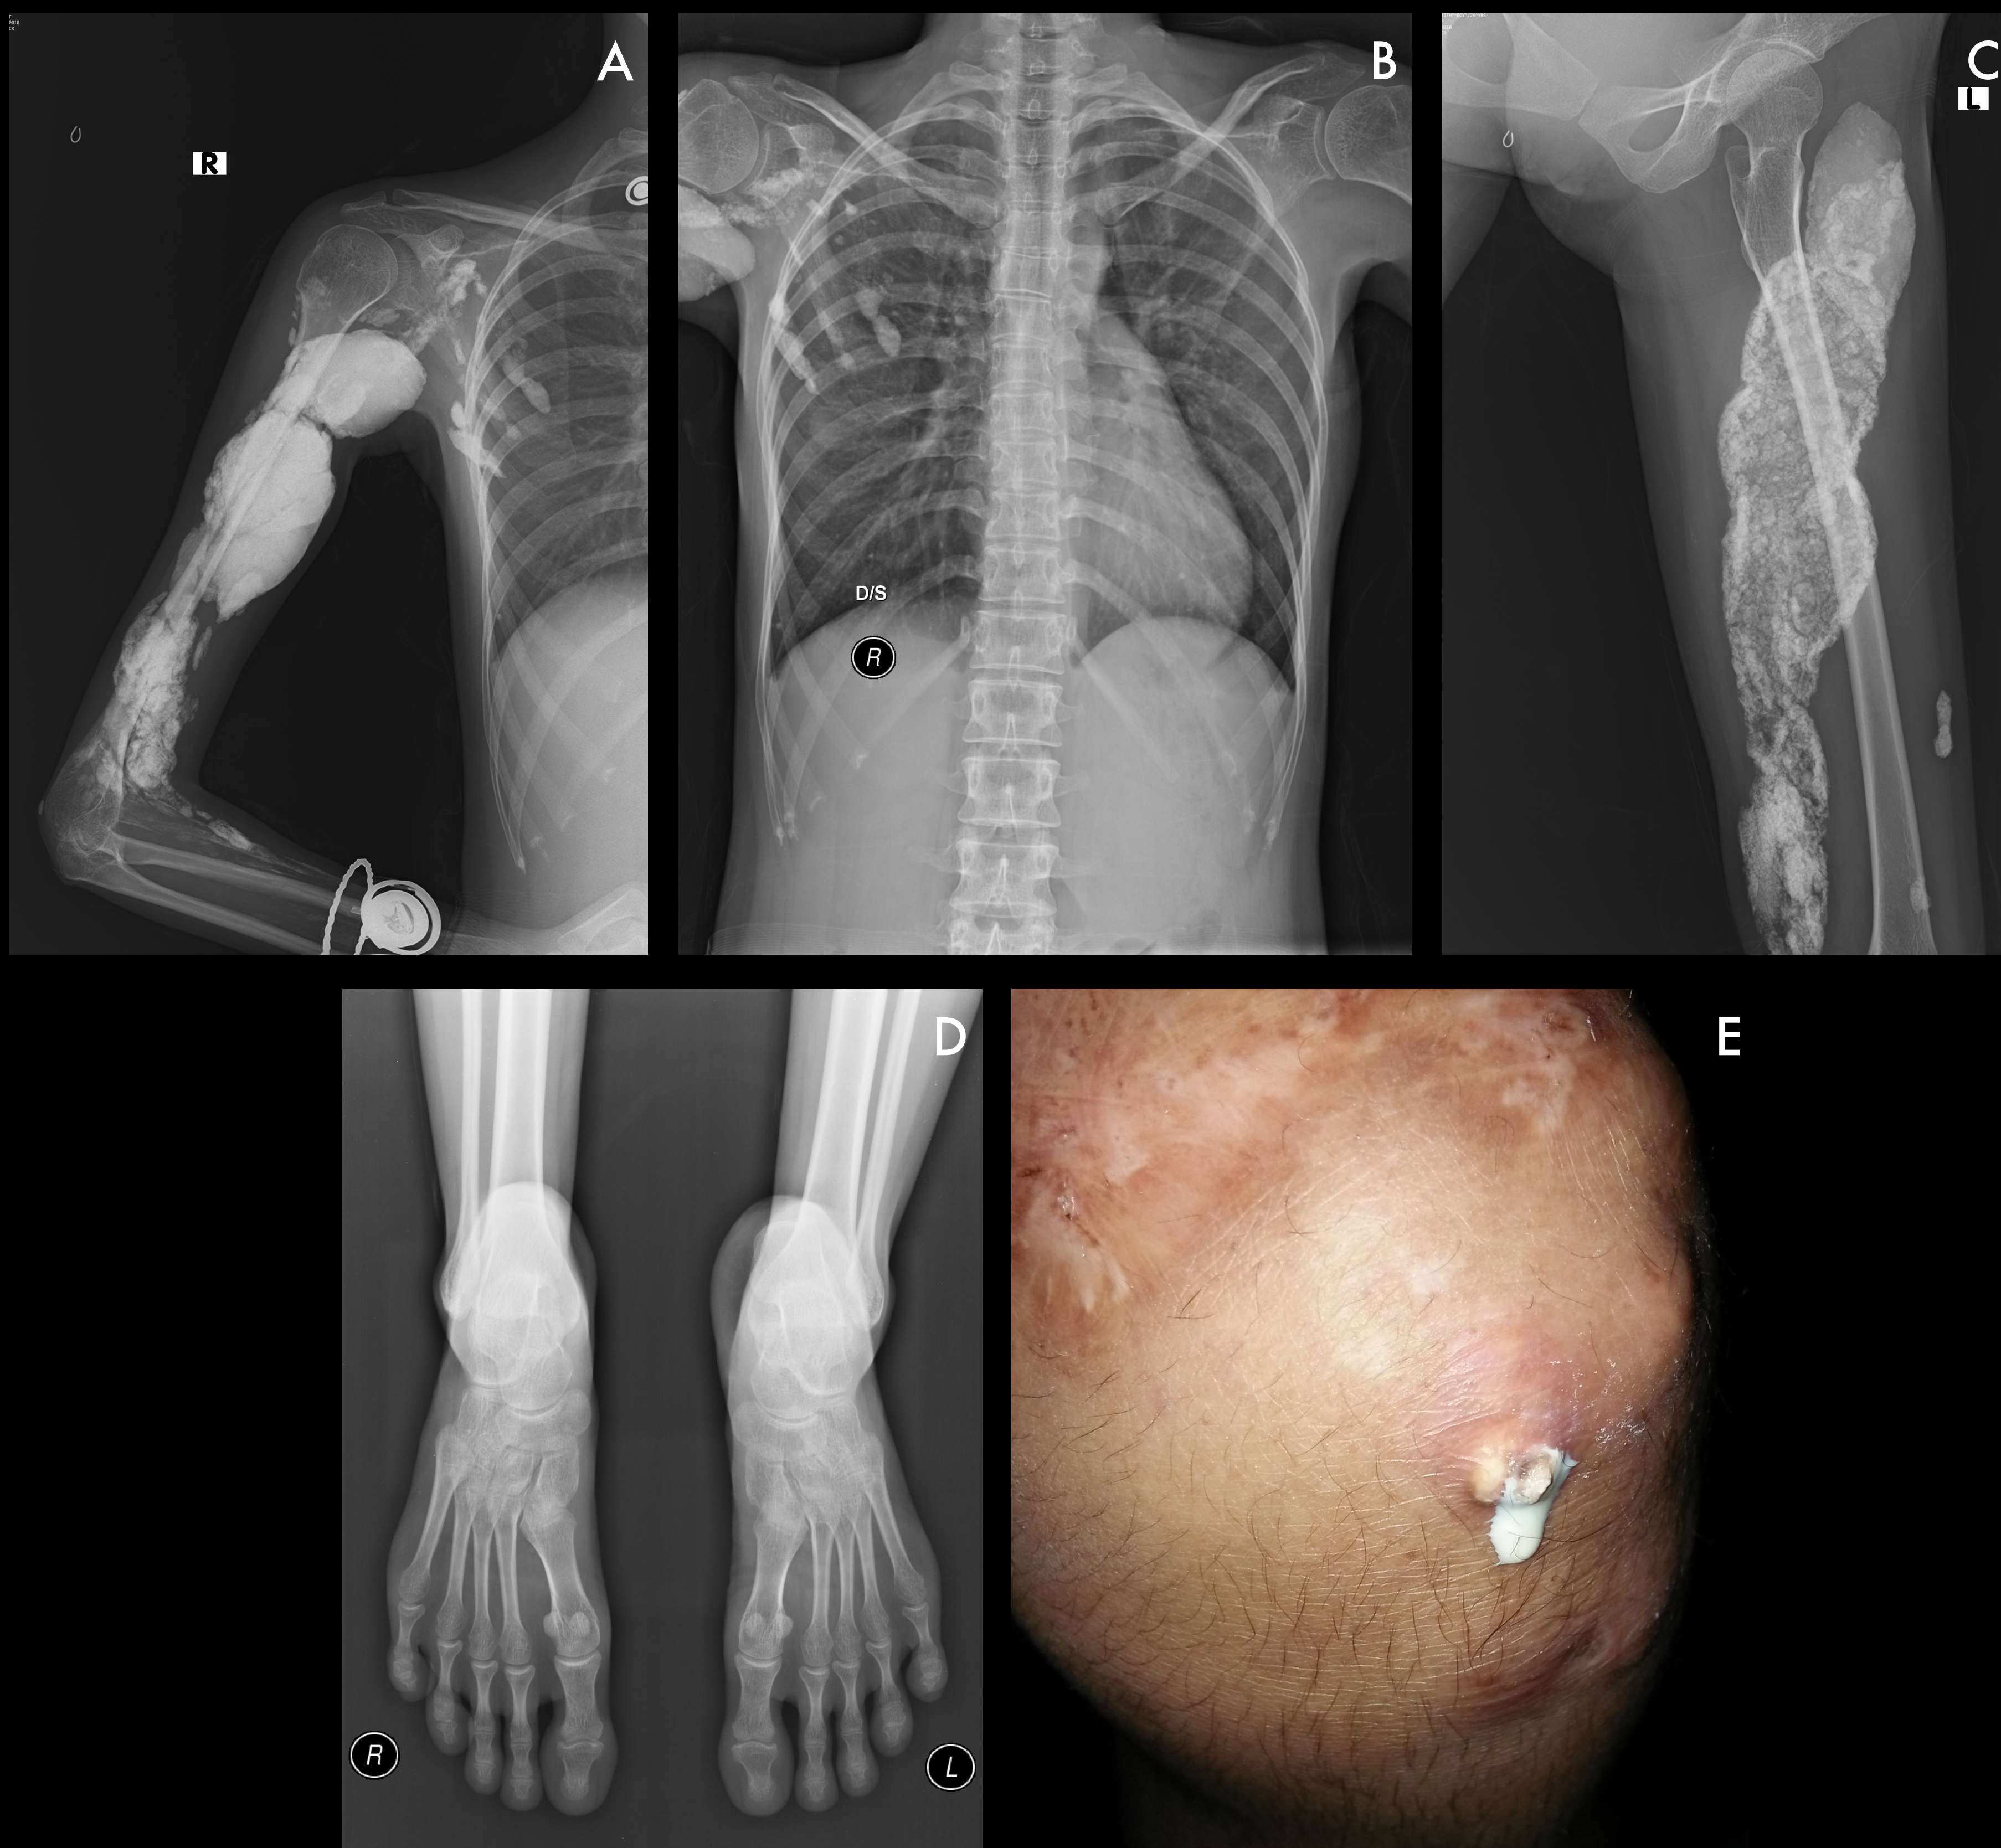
(A-D) Radiographs of the proband, showing extensive calcification in the soft tissue of the right upper arm (A), the pectoral and intercostal muscles (B) and left upper leg (C), separate from the underlying periosteum. Radiographs of the feet show no congenital deformation of the big toes (D). Indurations and irregular, hard, and painful skin lesions on the left knee accompanied by a white discharge (E).
